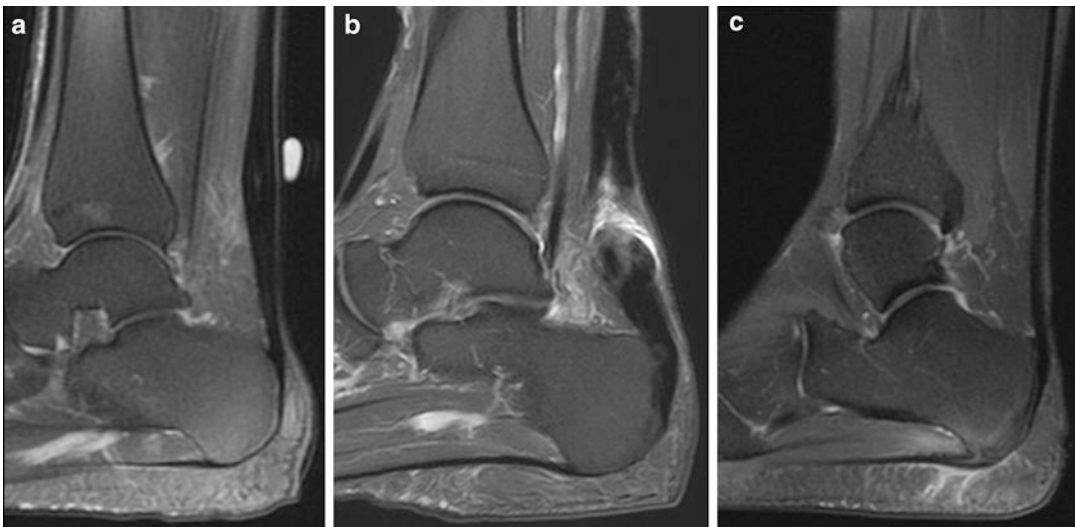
T2-weighted sagittal MRI images. (a) Aquilles tendinosis. (b) Aquilles complete rupture. (c) Plantar fasciitis
